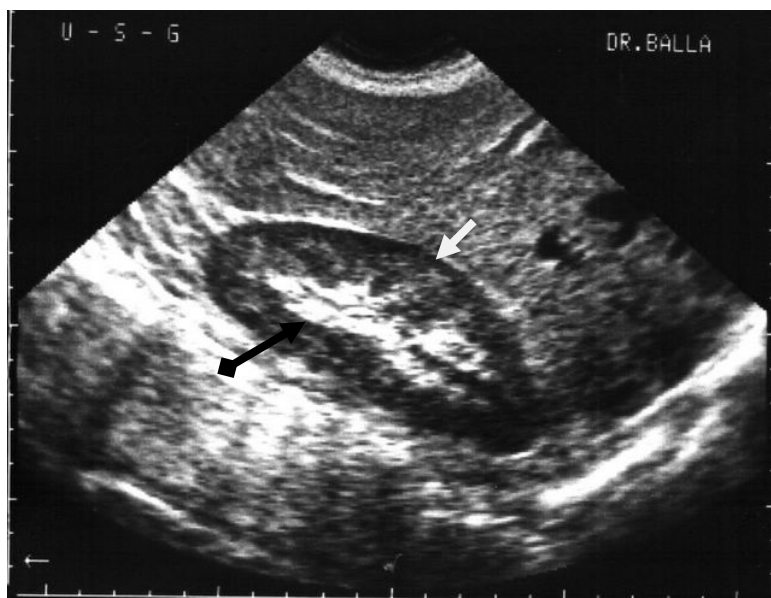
Ultrasound of the kidney in longitudinal direction. Peripheral zone represents parenchyma (hypoechoec, arrow). The central zone is detected as a congestion echoes with non-uniform reflection (arrow with a rhombus). Norm
